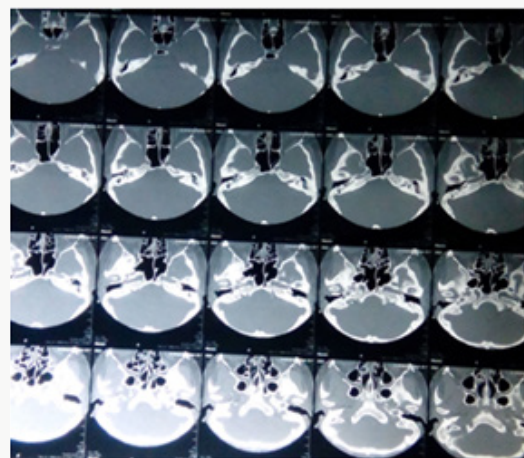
HRCT Temporal bone axial view.
